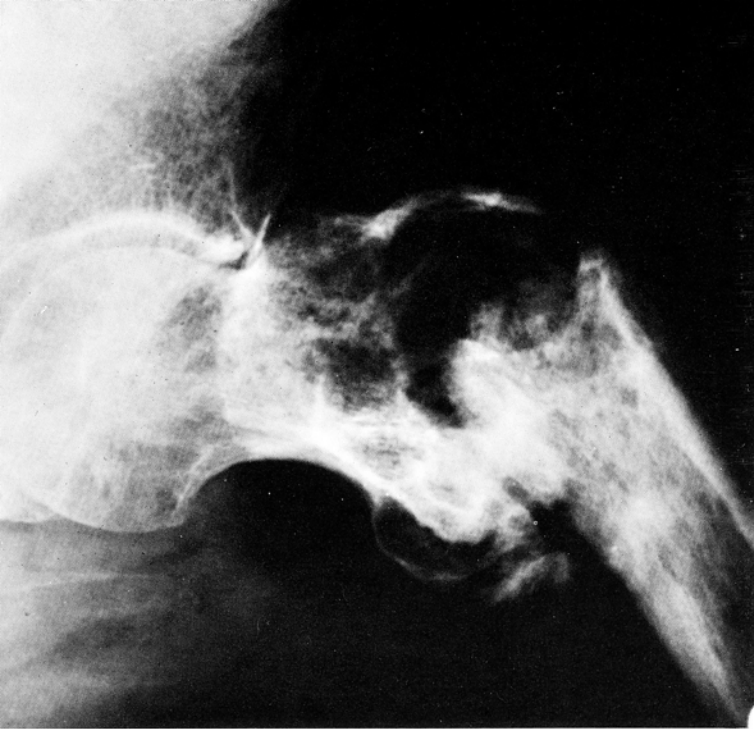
Roentgenogram taken in September, 1966, showing fracture but no recurrence of tumor after radiotherapy.
